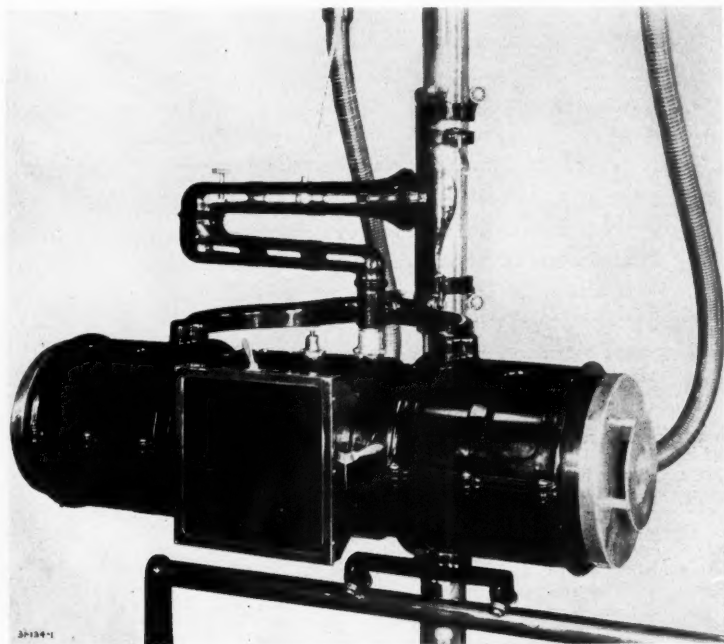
This recent American design consists essentially of a grounded metal drum, to which the high tension is conducted through ground-shielded, rubber-insulated cables. Ample air space and efficient ventilation enable the use of radiator tubes. For old style X-ray tubes this drum must contain lead shielding, making its weight rather formidable. Used with "autoprotective tubes," such a shock-proof shield need not be so heavy. Note the shutter handles, which control shutters for fluoroscopy.
